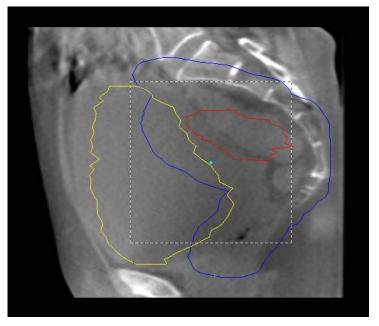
CBCT image demonstrating the potential impact of having a larger bladder than planned.
